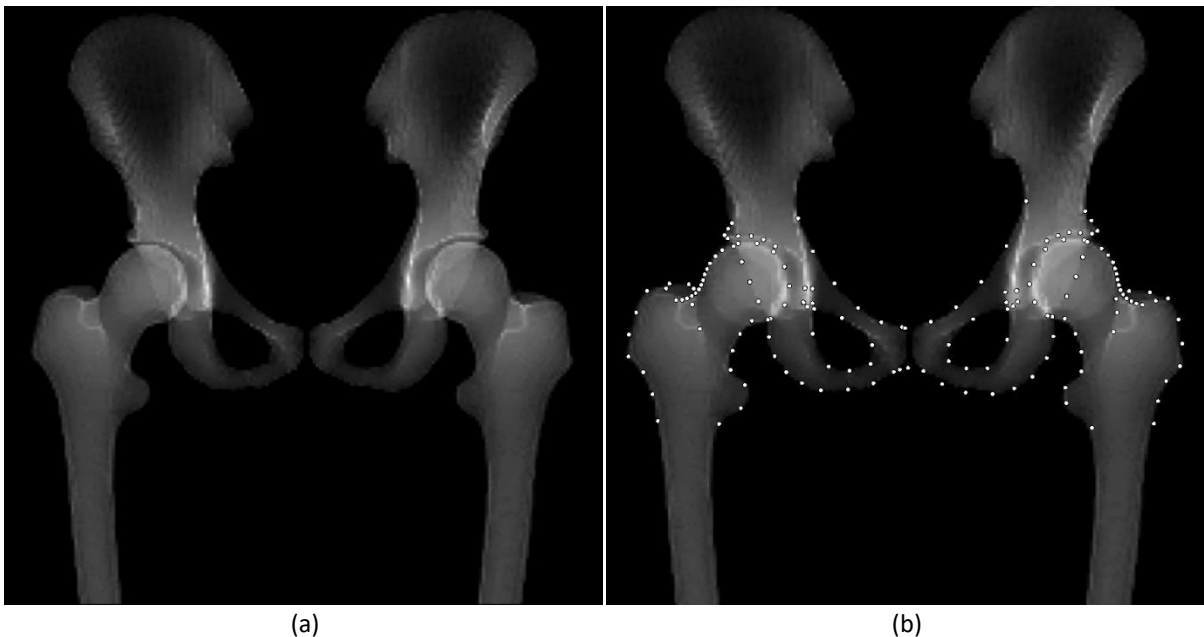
(a) A digitally reconstructed radiograph (DRR) created from a bone segmentation, created at neutral rotation. (b) Landmarks on the DRR shown in subfigure (a).
